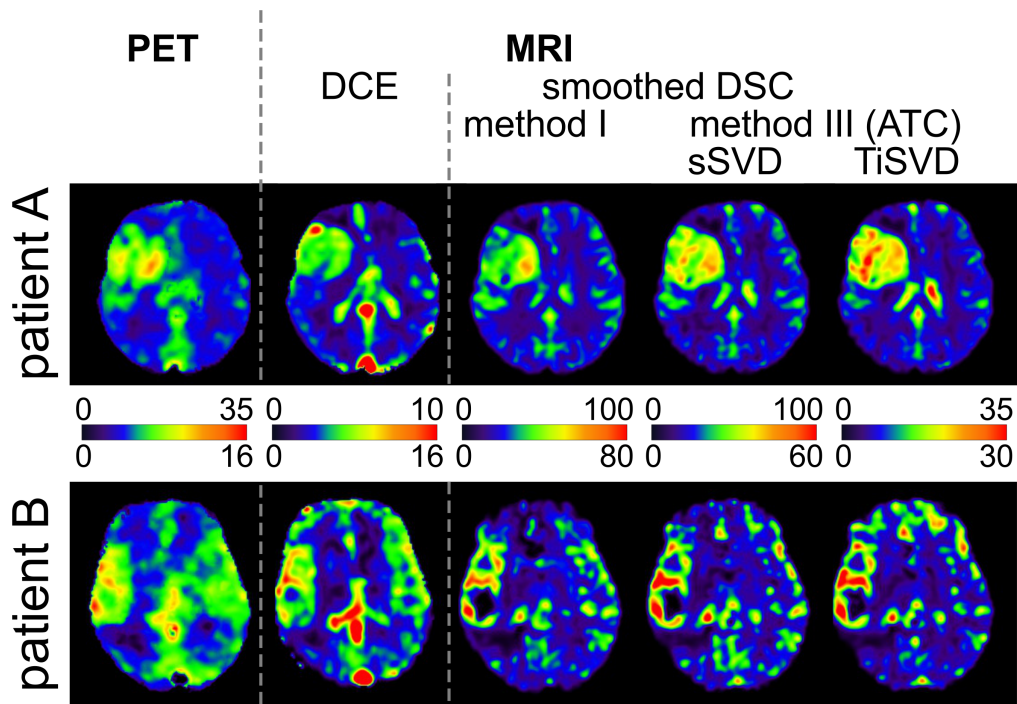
Exemplary CBV parameter maps obtained from dynamic [^{18}F]FET-PET, DCE-MRI and DSC-MRI in two patients A and B. One slice is shown for each patient and three extravasation corrected CBV_{DSC} maps (smoothed for visual inspection). Please note that the range of absolute CBV values largely disagrees as indicated by the different color codes that are displayed in the middle row of the figure in units of ml/100 g.
